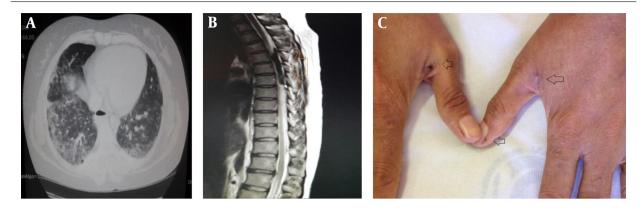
A, Chest high resolution computerized tomography scan showing bilateral lung infiltration and ground glass appearance; B, Thoracic MRI showing upper thoracic subdural hematoma; C, both hands' small necrotizing palpable vasculitic lesions.
